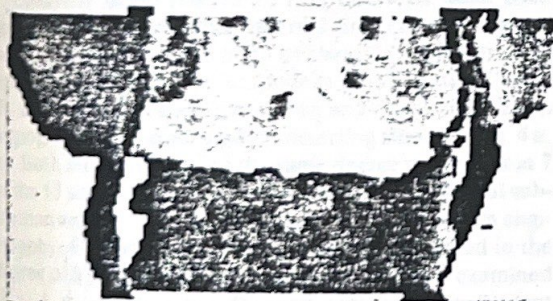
Cemax 'transparent 3-D' of the cervical carotid arteries. Transparency of the mandible where the carotid branches lie beneath it affords improved demonstration on this CT study. Surgical planning is facilitated by demonstrating these vascular-bone regional relationships.
